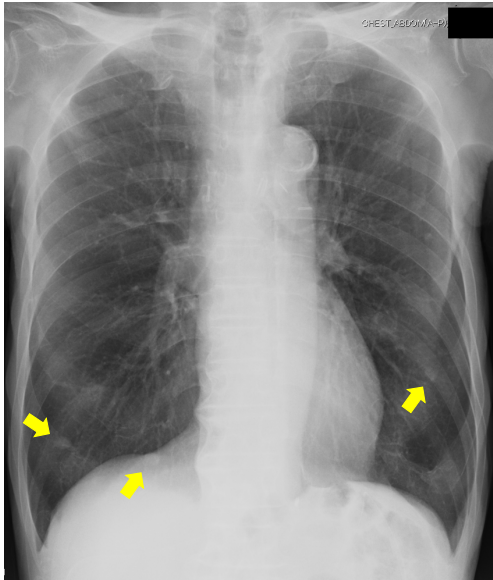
80-year-old male with lung metastases after esophageal cancer surgery. Nodules 9 mm and smaller are difficult to distinguish on digital chest radiographs.
